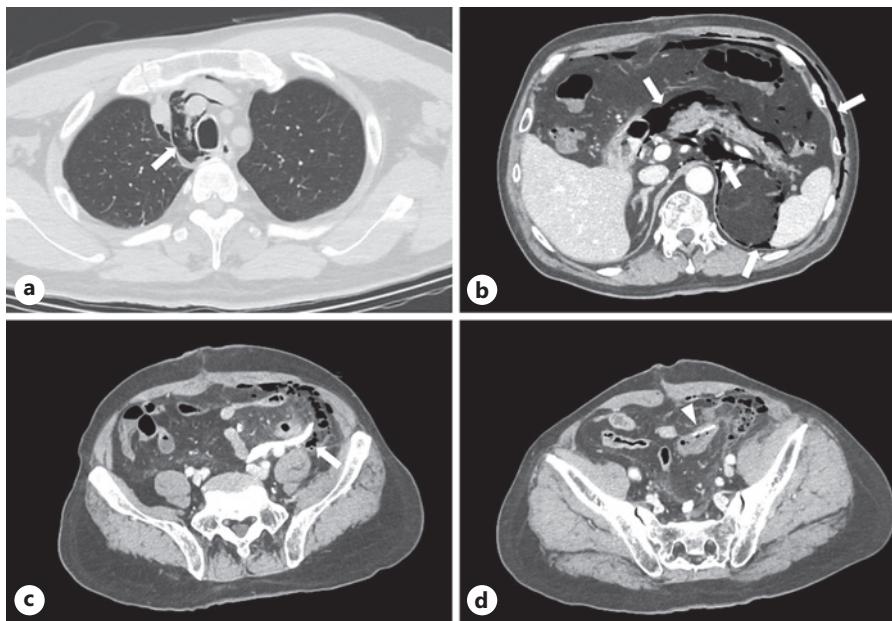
Computed tomography on postoperative day 3 shows mediastinal emphysema (a), retroperitoneal emphysema around the pancreas (b), retroperitoneal emphysema at the dorsal descending colon (c), but no fluid or air collections around the anastomosis (d). Arrows: areas of subcutaneous, retroperitoneal, and mediastinal emphysema. Arrowhead: area of the anastomosis.
